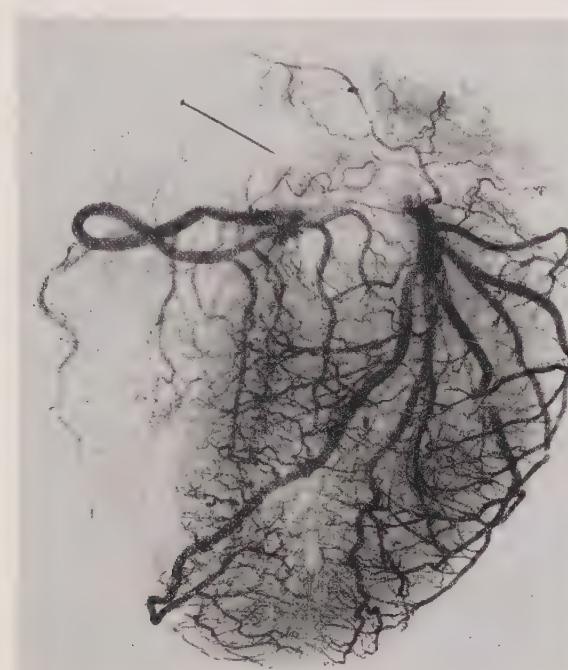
Roentgenogram of injected coronary circulation in a normal adult heart. (From Gross: *The Blood Supply to the Heart*, Paul B. Hoeber, Inc.)
